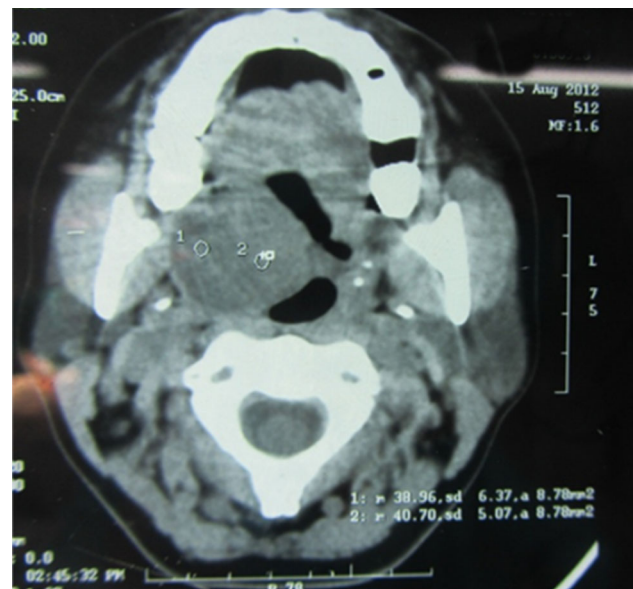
CT scan of lesion showing extension of lesion
